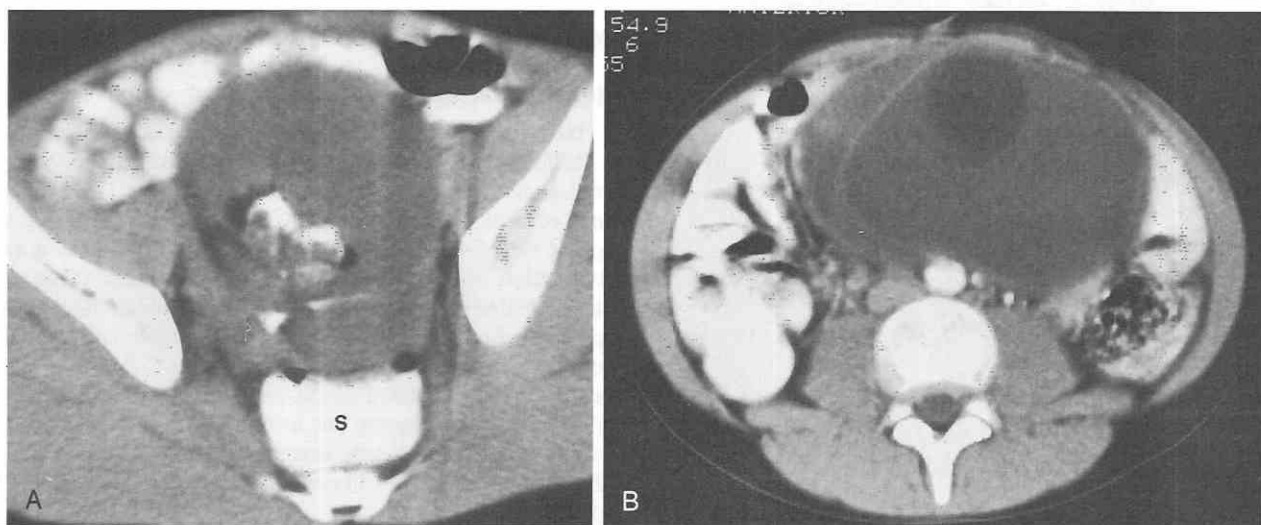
Benign ovarian teratoma in 15-year-old girl with pelvic pain. A, Contrast-enhanced CT shows a well-defined, low-attenuation mass anterior to the sigmoid (S) colon. Toothlike calcifications and fatty tissue are seen within the mass. On pathologic section, the teratoma contained predominantly sebaceous fluid and small amounts of hair, bone, and fat within several mural nodules. B, CT scan in another patient shows a low-attenuation mass with a septation and an intracystic fat ball.
